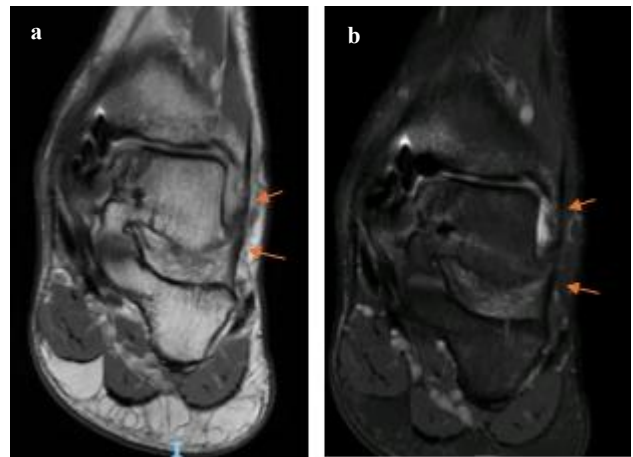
(a and b): MRI coronal image IN T1 and T2, evidencing the AFCM (orange arrow).
